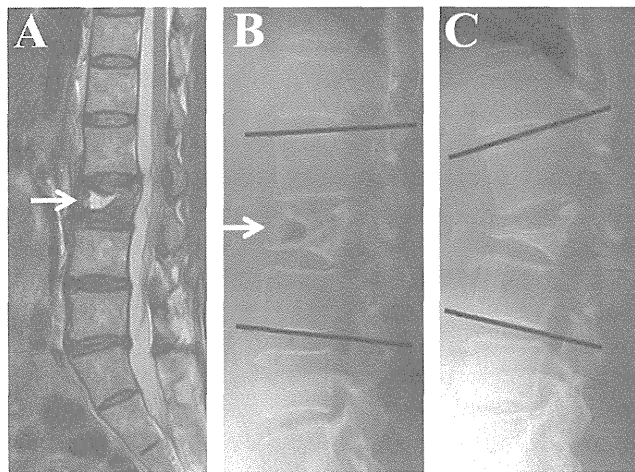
Preoperative magnetic resonance imaging (a). Preoperative lateral X-rays in supine position (b) and standing position (c). The white arrows indicate the cleft in the L3 vertebrae
